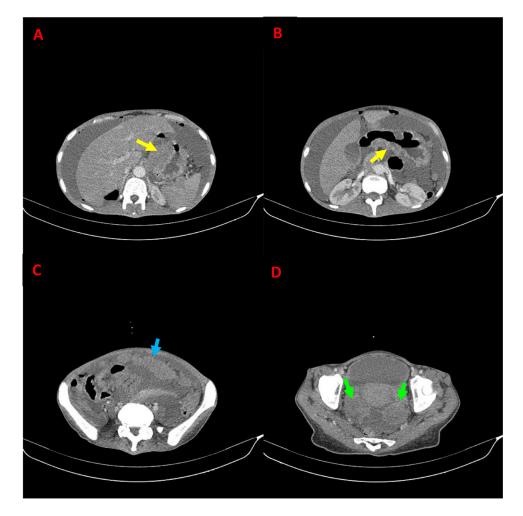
axial CT scan images showing thickening of the stomach wall (yellow arrows) with omental cake (blue arrow) and ovarian metastasis (green arrow). Color version of figure is available online.
